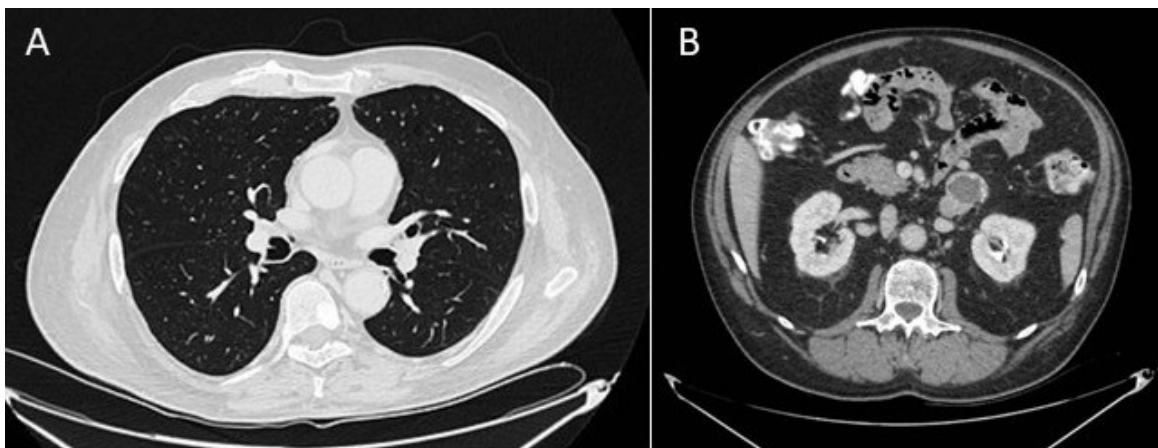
Computed tomography of the chest and abdomen. *A.* Dense, blastic-appearing focal lesion in the T7 vertebral body. *B.* Heterogeneous lesion in the left adrenal gland with peripheral calcifications peripheral contrast enhancement, and a central hypodense area.
